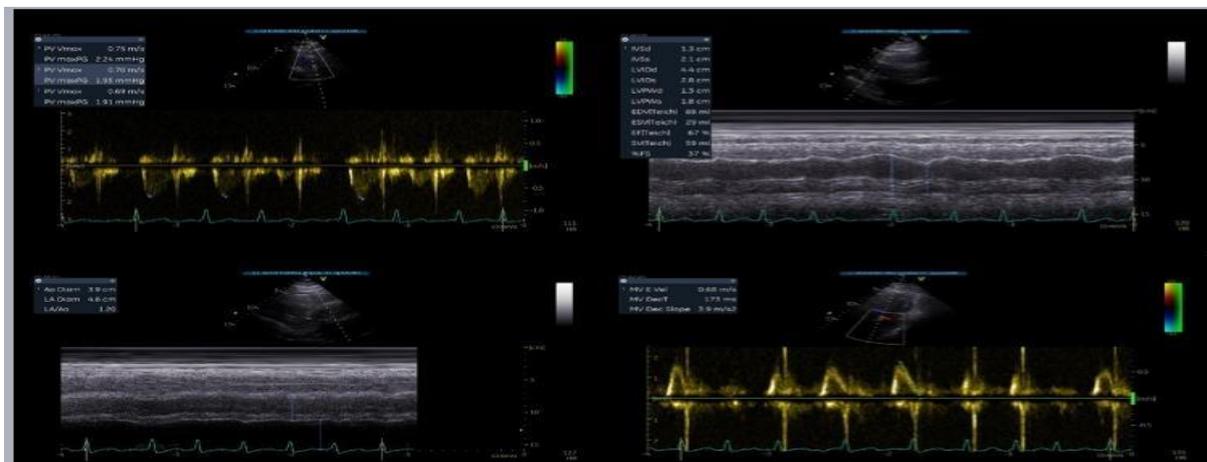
Trans-Thoracic Echocardiography findings.
